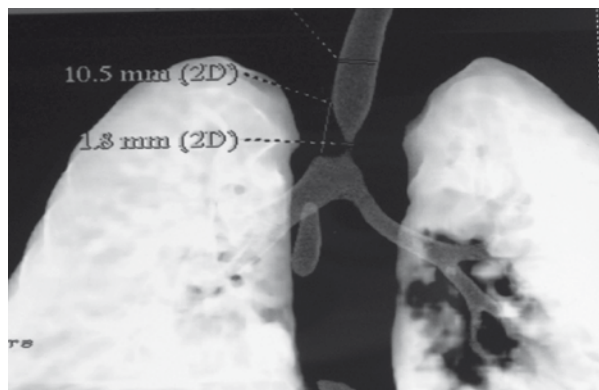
Computed tomography at the age of 4 months: severe tracheal compression due to a double aortic arch
